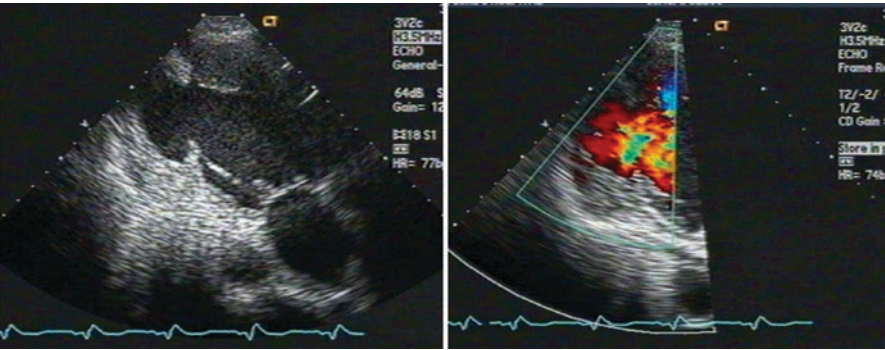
Apical three-chamber view (left) obtained from transthoracic echocardiogram revealing a large left ventricular aneurysm, enhanced with color flow Doppler (right) establishing an area of communication between the normal left ventricle and the aneurysmal portion
